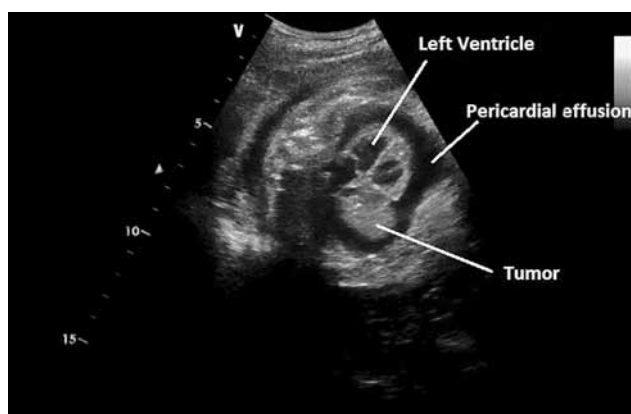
Fetal echocardiography showing the intrapericardial cystic mass and effusion.
